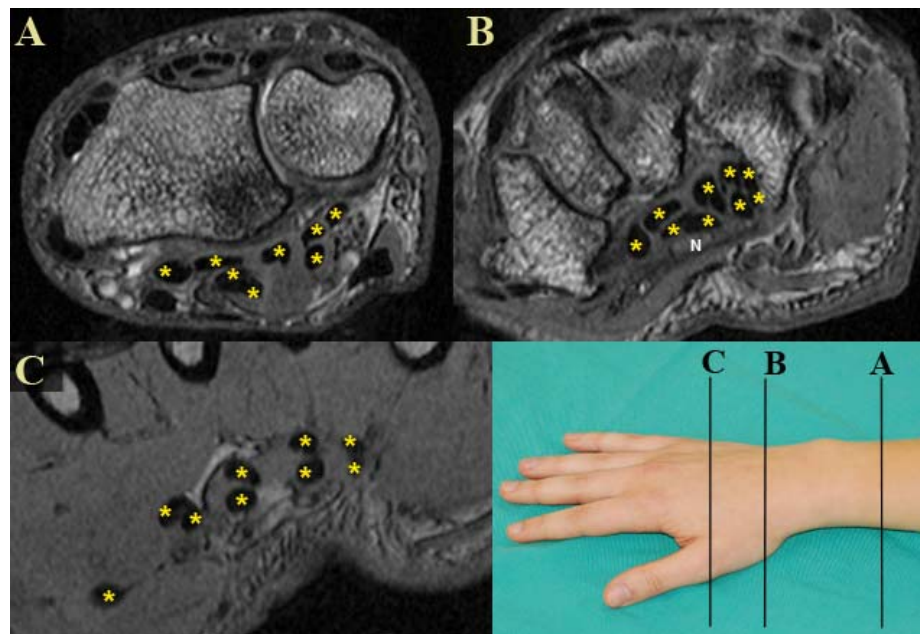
MR images with flexor tendons identified (\*) within (B), and on either side of (A&C) the carpal tunnel. Only in the distal image from the hand (C), where the tendons align in pairs going to each finger (one to the thumb) and in two layers (deep and superficial), was unambiguous tendon identification possible.
